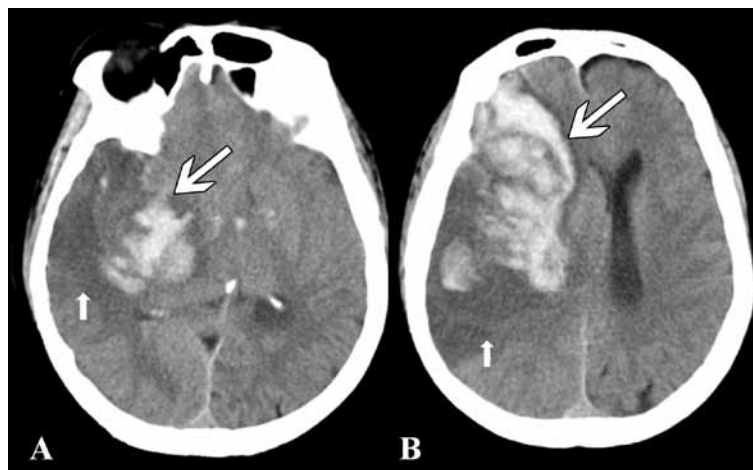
A preoperative CT scans showed: A) right malignant middle cerebral artery infarction (short arrow); and B) massive intracerebral hemorrhage (long arrow).
